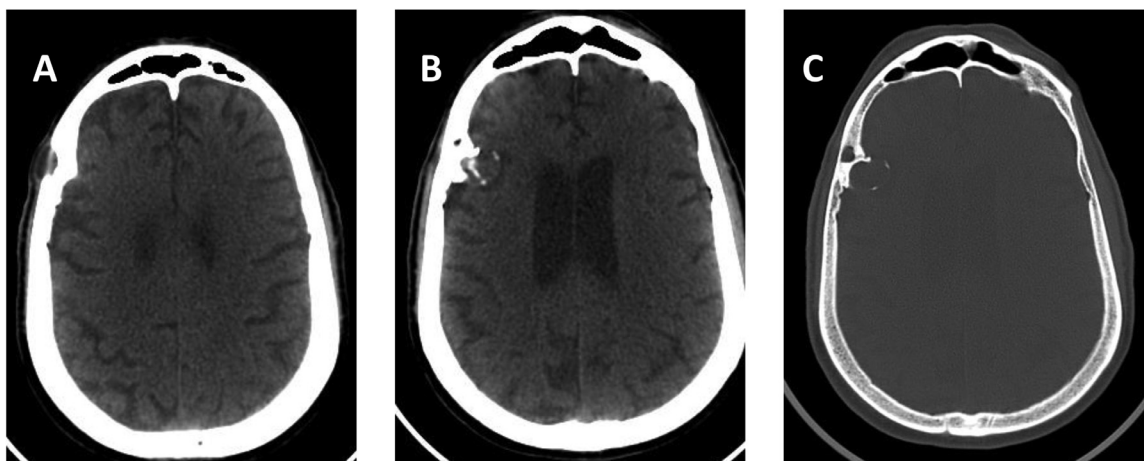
Computed Tomography scan axial images on parenchymal (A) and bone reconstruction (C) showing an extra-axial round-shaped lesion, hypodense, with margined calcifications located on the calvarial frontal right bone, associated with condensation of the inner table and erosion of the outer table.
